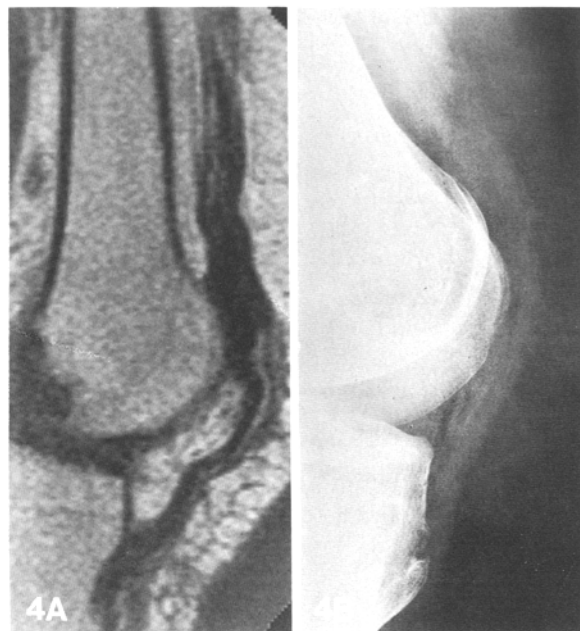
A Sagittal MR image in a patient following patellectomy. Patellar tendon has a “wrinkled” appearance. B Lateral knee radiograph of same patient also demonstrates a “wrinkled” appearance of the patellar tendon
